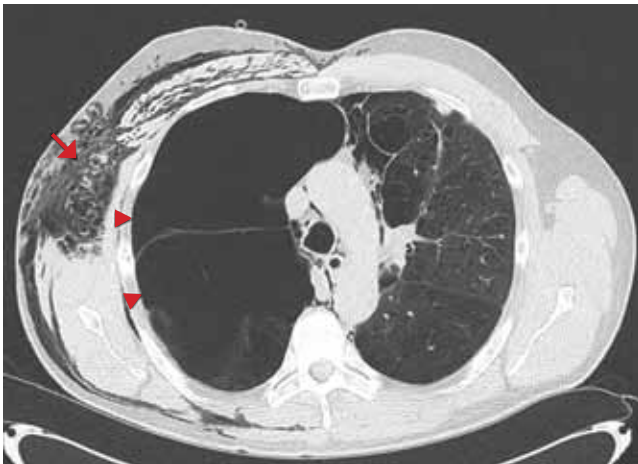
Computed tomography of the chest shows extensive subcutaneous emphysema of the right lateral chest wall (arrow), large bullae in the right upper lobe (arrowheads), and pneumomediastinum.
